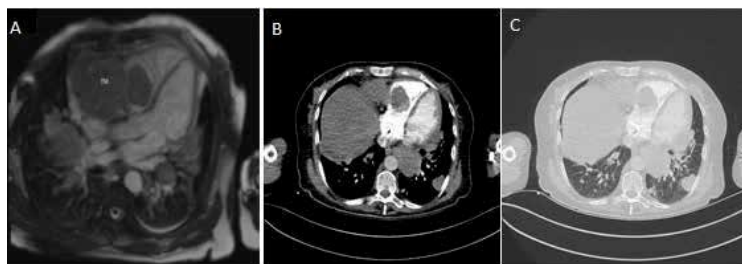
Metastases spread from neighboring mediastinal mass into the right heart chambers on cardiac magnetic resonance imaging Figure 2B and 2C: Lung and cardiac metastases of the uterine leiomyosarcoma on computed tomographic angiography
